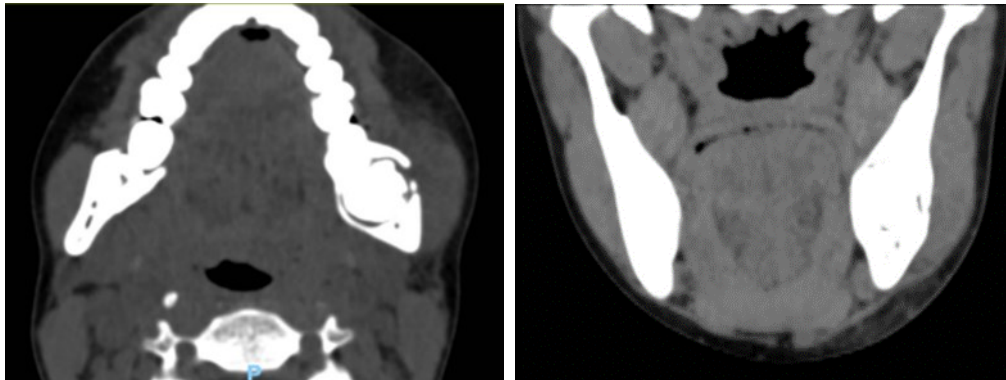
Showing a hypodense image with lingual and buccal bone expansion from CT. Left to right (A.) axial view and (B) coronal view
